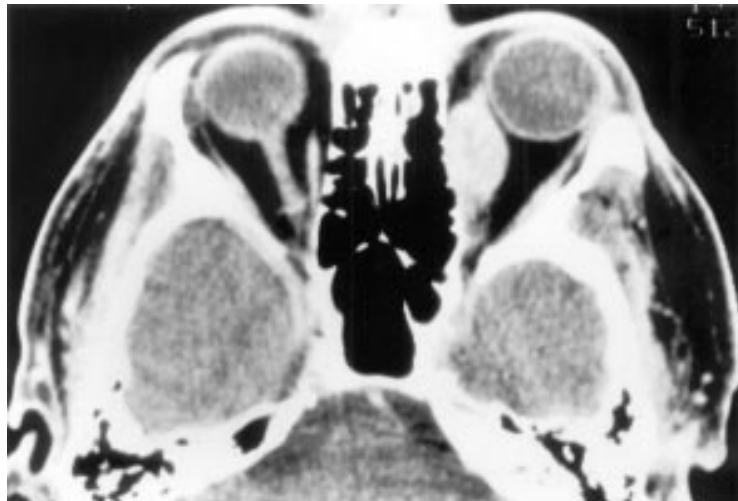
Focal area of muscle enlargement is a typical radiological finding in some orbital metastases. This is noted on axial computed tomography.
